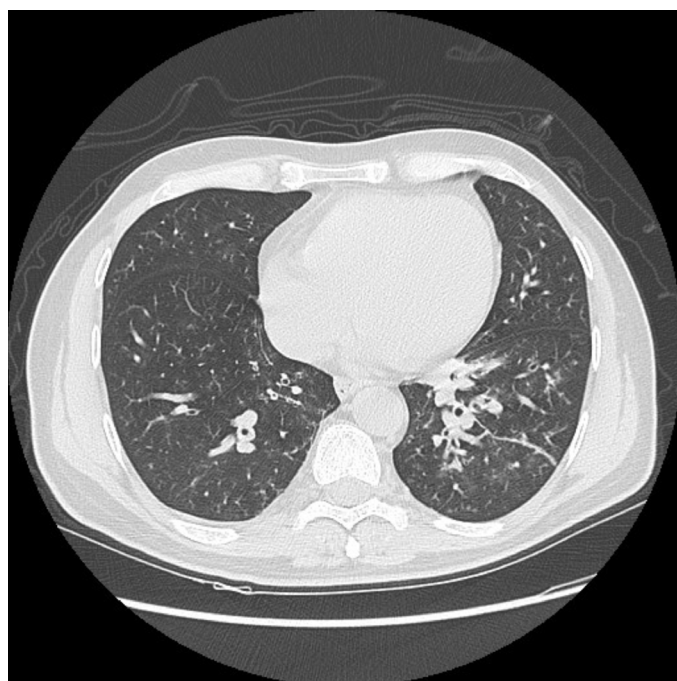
Chest computed tomography (CT) scans before antifungal therapy. A chest CT scan showed bronchial wall thickening and peribronchovascular interstitial hyperdensity of the lower left lobe, especially of the basal pyramid, blurred alveolar micronodules in the dorsal subpleural region of the right lower lobe and the juxtascissural site, in the anterior segment of the right upper lobe; mediastinal adenopathies (short axis around the cm in Baretty and subcarinal) were also documented (Figure 1-4). 127×92 mm (300×300 DPI)
